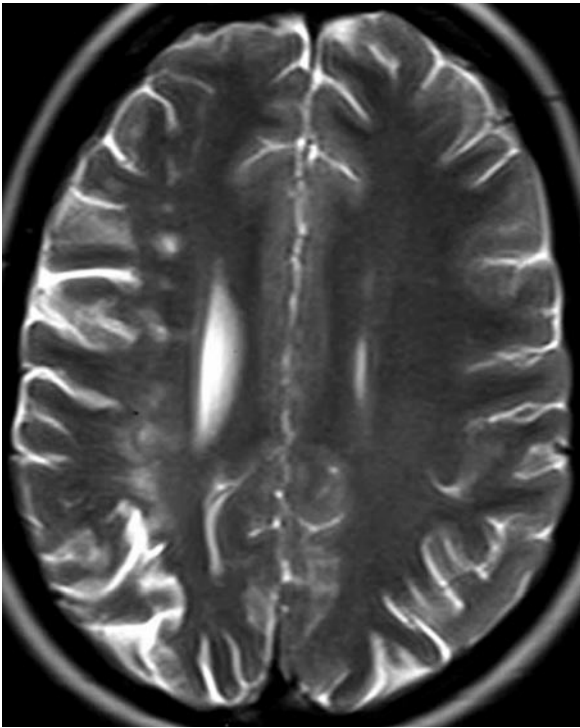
(continued) Moyamoya disease. c Axial T2-weighted image demonstrates increased signal in the right hemispheric border zone due to cortical and white matter ischemic infarcts. The prominent ipsilateral sulci are due to cortical atrophy. (From ERTL-WAGNER 2007)
